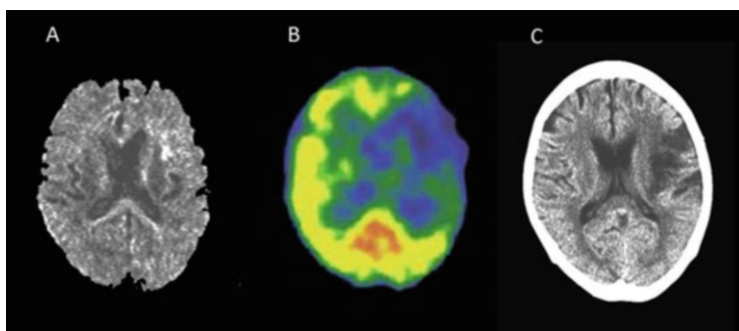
Prediction of cerebral infarction by acute CBF-SPECT. A diffusion-weighted MR image obtained at 1.3 h after onset (a) demonstrated only a small lesion in the frontal lobe. A $^{99\text{m}}\text{Tc}$ -HMPAO-SPECT image obtained at 2.3 h after onset (b) showed a broad reduction in CBF in the left cerebral hemisphere. A CBF reduction of more than 50 %, compared with the contralateral region, was observed in the left frontal lobe, and this area progressed into a complete infarction visible on a CT image obtained 4 days after onset (c)
